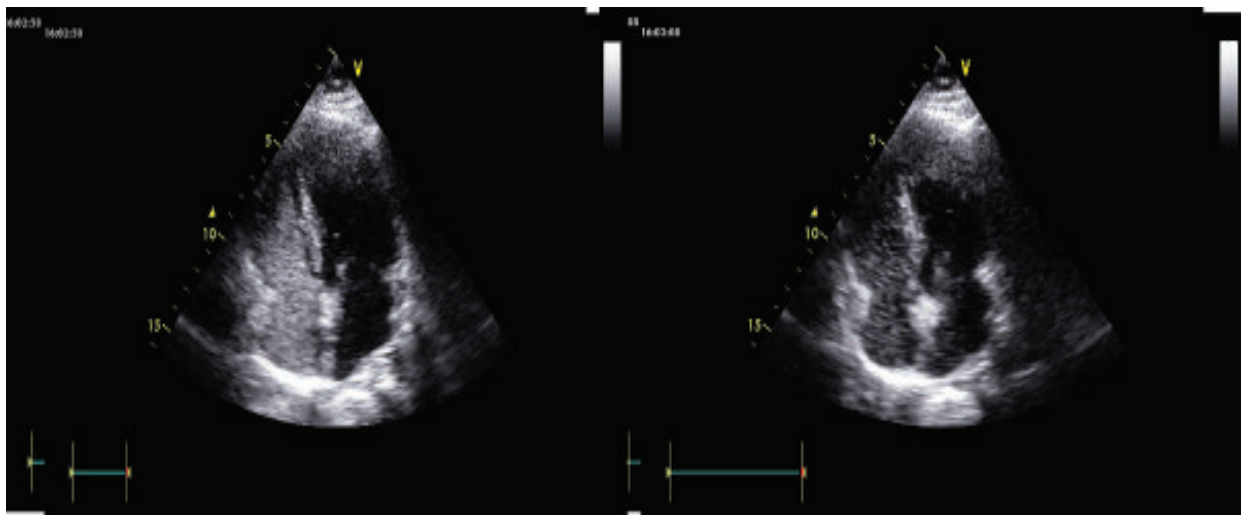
Contrast echocardiography showing presence of PFO.
